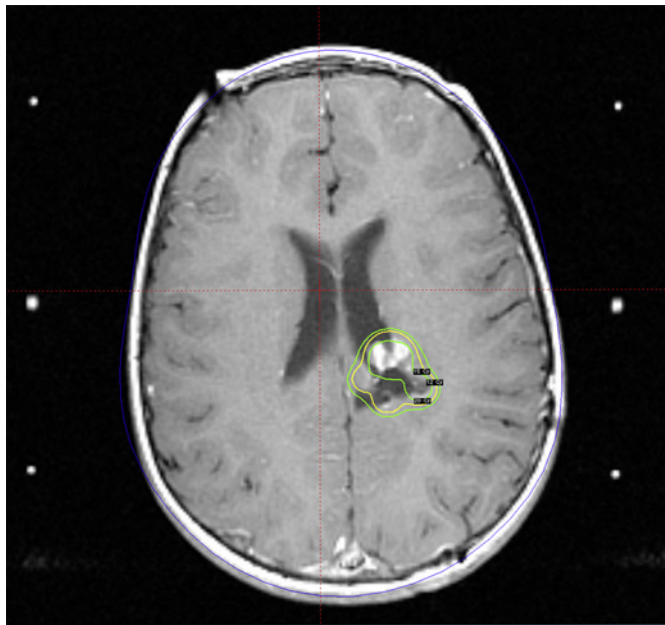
MRI of a representative treatment plan in a pediatric patient who had a recurrence at the anterior margin of the prior resection cavity. The 20, 15, and 12 Gy isodose lines are denoted.
